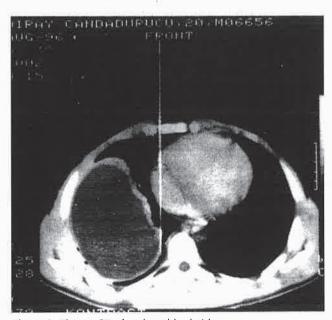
Thorax CT of a pleural hydatid cyst
